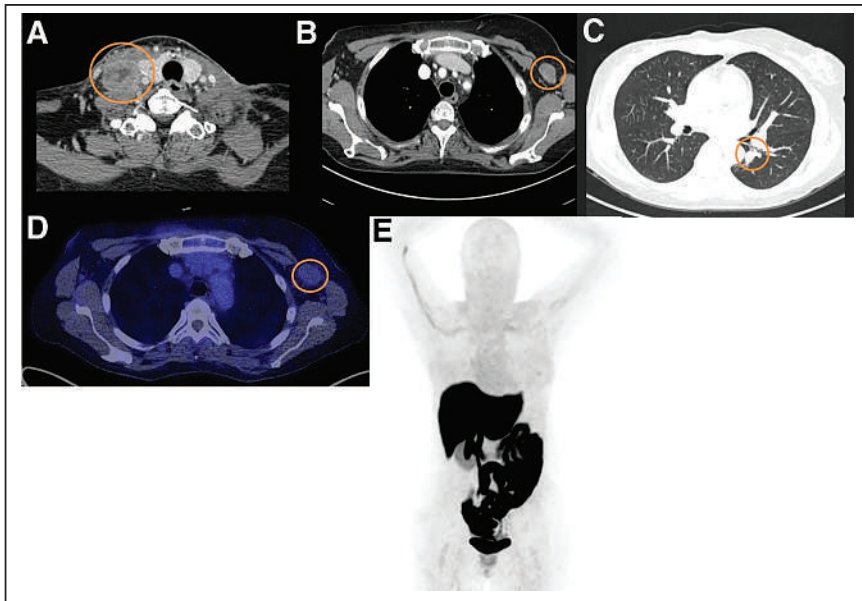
Inability to determine which primary tumor caused metastases. A 63-y-old woman known to have oral squamous cell carcinoma was recently diagnosed with ER-positive BC. At physical examination, a palpable mass was found in right neck region (level IV) and was also visible on CT (A). In addition, enlarged lymph node was visible in left axilla on CT (B), as well as abnormality in left lung (C). The dilemma was whether these metastases were associated with ER-positive BC or oral squamous cell carcinoma. ^{18}F -FES PET was performed to evaluate whether these lesions were metastasis from BC (in case of ^{18}F -FES-positive findings). However, ^{18}F -FES PET did not show any significant tracer uptake in metastatic lesions (D and E). ^{18}F -FES PET result did not solve dilemma, because there could be conversion from ER-positive to ER-negative status; therefore, biopsy of left axillary area was performed and confirmed presence of squamous cell carcinoma.
